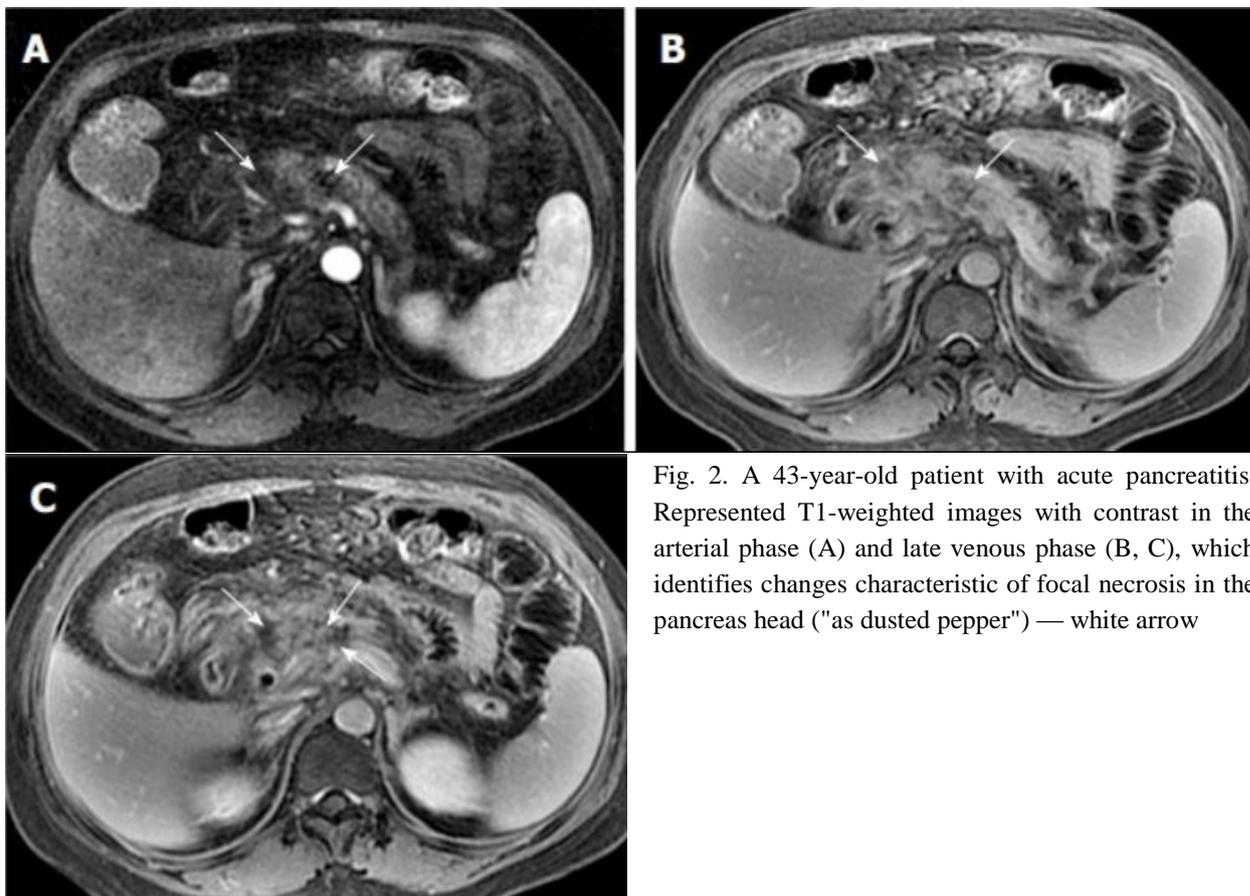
A 43-year-old patient with acute pancreatitis. Represented T1-weighted images with contrast in the arterial phase (A) and late venous phase (B, C), which identifies changes characteristic of focal necrosis in the pancreas head ("as dusted pepper") — white arrow
